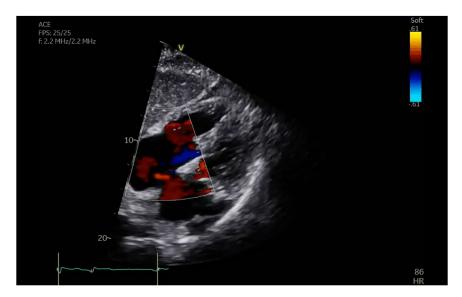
Predischarge echocardiography with left-to-right shunt.
